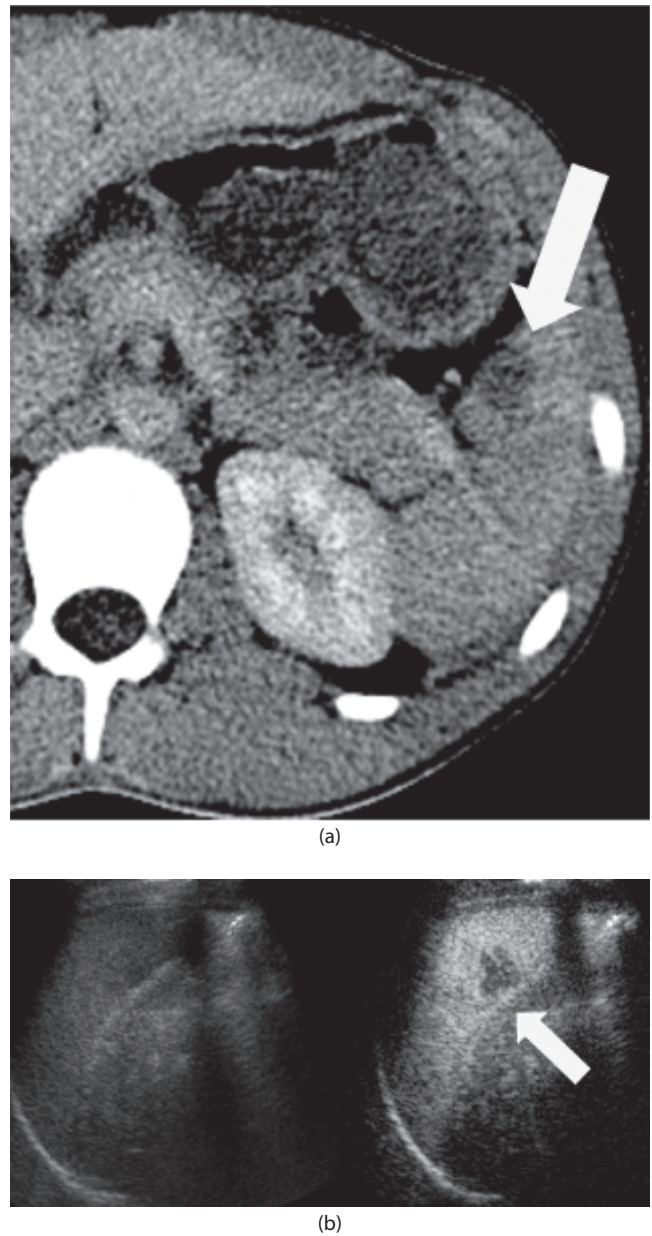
Contrast-enhanced ultrasound images. (a) CT demonstrating a grade II splenic laceration. (b) In the same patient, the laceration is not noted on a standard ultrasound (left), but is clearly demonstrated on contrast-enhanced ultrasound (right). (Courtesy of Dr. David Mooney, Boston Children’s Hospital.)
